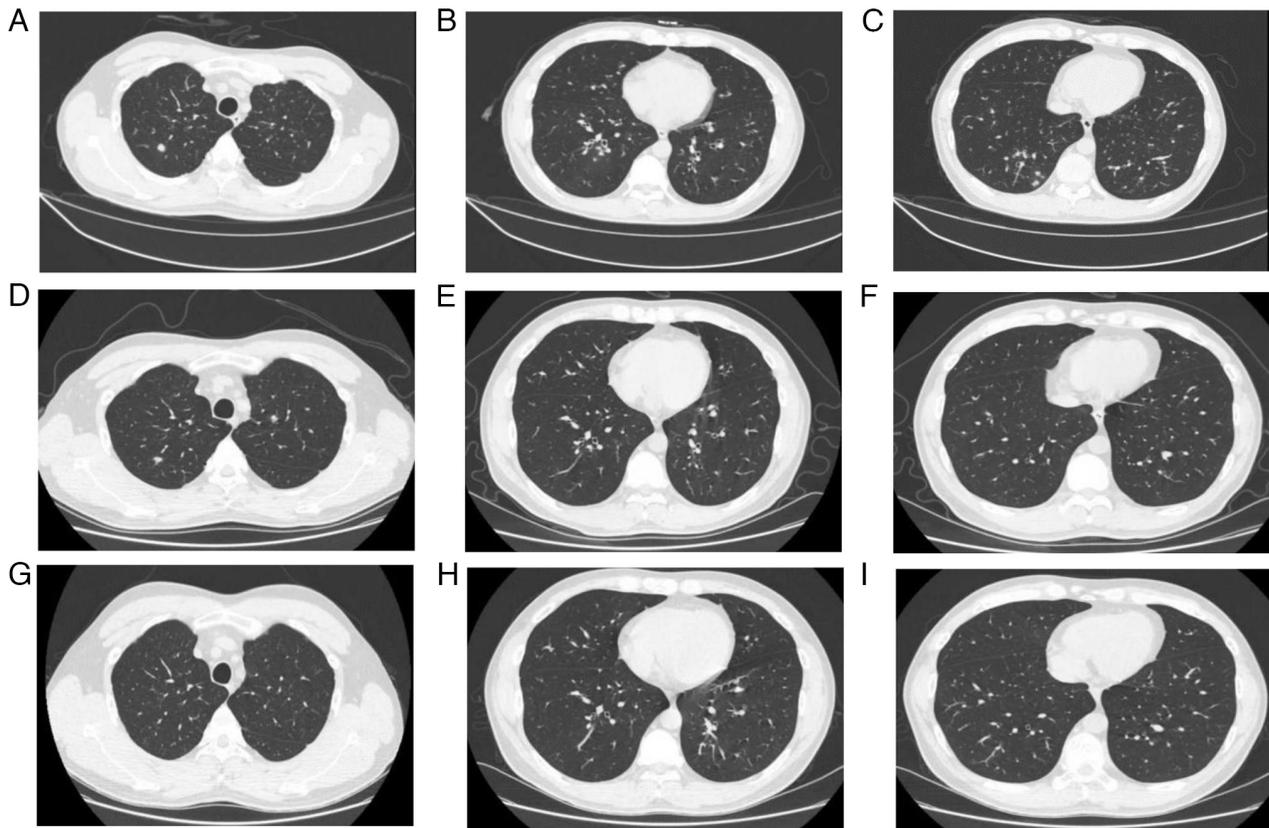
Comparison of chest CT in patient 2. (A-C) Chest CT in March 2023. (D-F) Chest CT in April 2023. (G-I) Chest CT in August 2023. The lesions were more clearly absorbed in August compared with in March.
